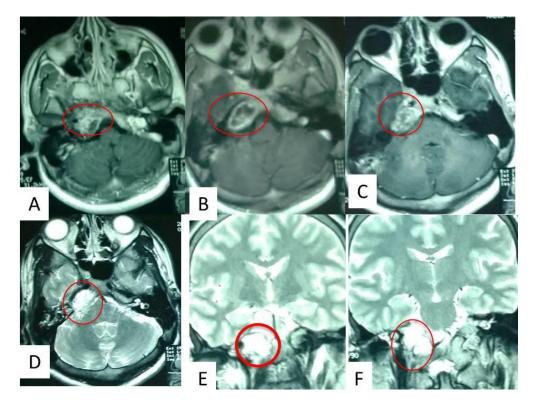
MRI of head; A,B&C-contrast axial images showing irregularly contrast enhancing lesion in right petrous apex. D- axial, E&F coronal T2W images showing hyper intense bony lesion in right petrous apex (ABC)
